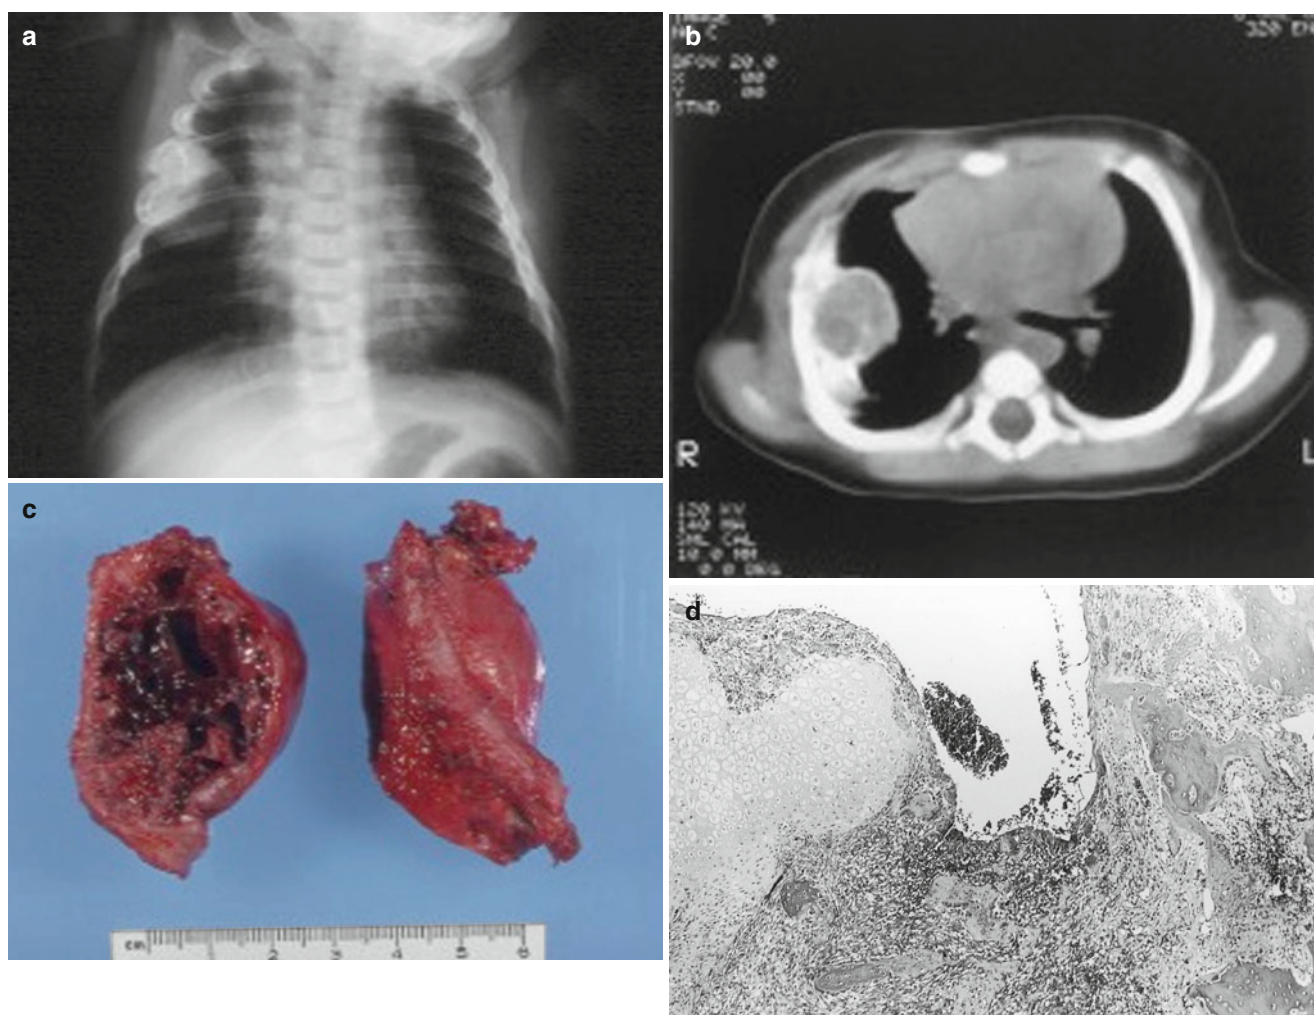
Chest wall hamartoma. Five-month-old male with a chest mass. (a) A cystic, expansile lesion involves the right fourth rib. Scoliosis and a chest wall deformity present here can be serious complications of the hamartoma. (b) CT scan reveals a defect in the right chest wall and a cystic lesion bulging into the thoracic cavity. (c) The involved
